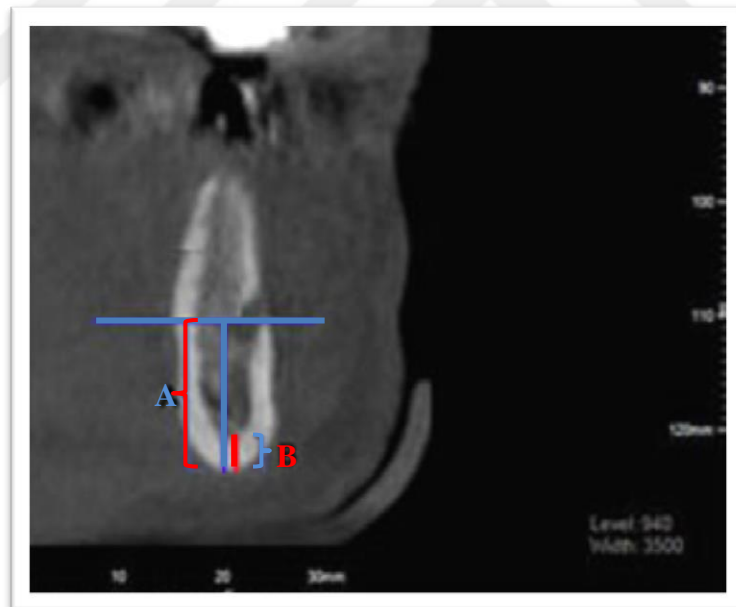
Measurement of Mental Index (A) on CBCT image.
